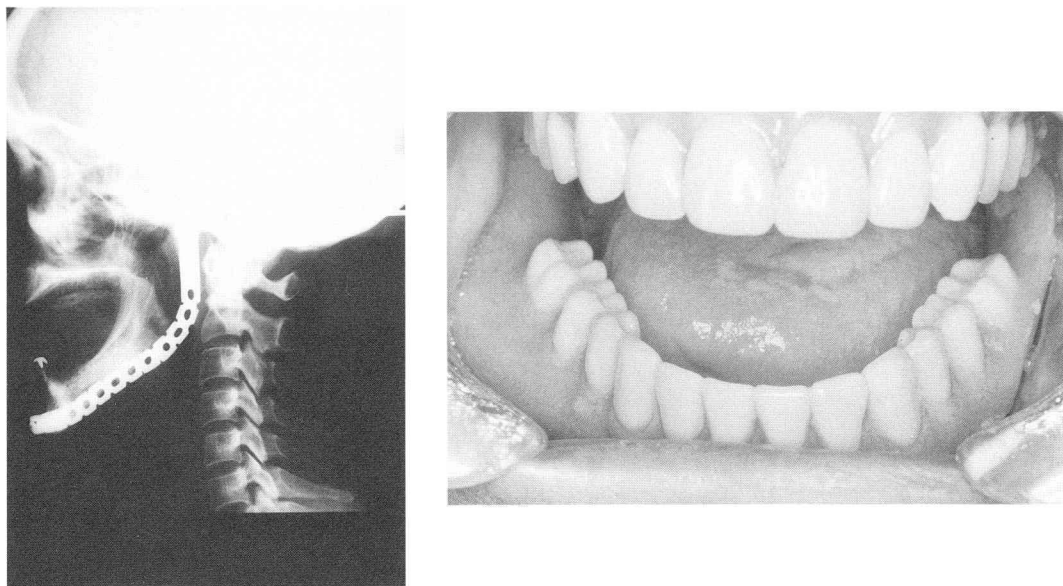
Lateral X-ray view of the reconstruction plate of mandible at 2 years and 7 months after operation. It shows the stabilized denture.
